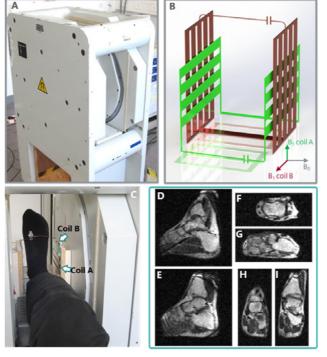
A) 0.1 T extremities MRI system. B) Open quadrature volume RF detector. C) foot positioning. D-I) slices from the same 3D bSSFP scan of an ankle, 7 min 54 s, resolution $0.8 \times 0.8 \times 1.1$ mm3 (pictures: M. Yushchenko).
